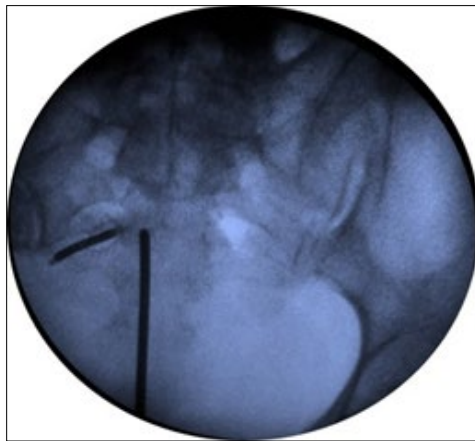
Anterolateral radiograph of abdomen and pelvis with uterine sound *in situ*.
